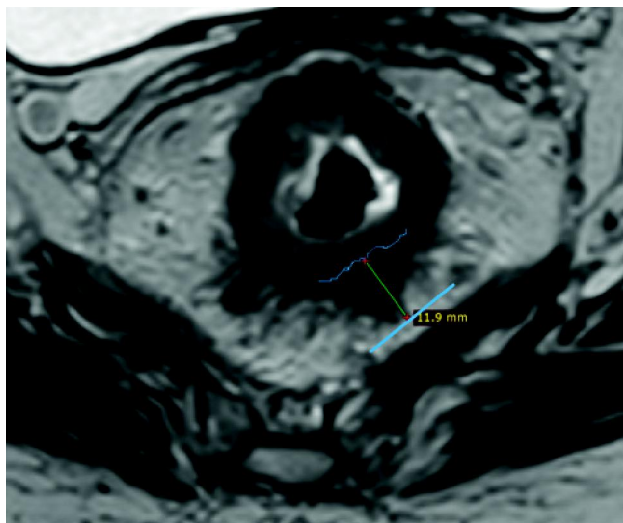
Oblique axial thin-section T2-weighted MR images showing extramural tumor invasion. Note the nodular intermediate signal intensity tumor invading the mesorectal fat with the depth of invasion measuring 11.9 mm (T3c).
